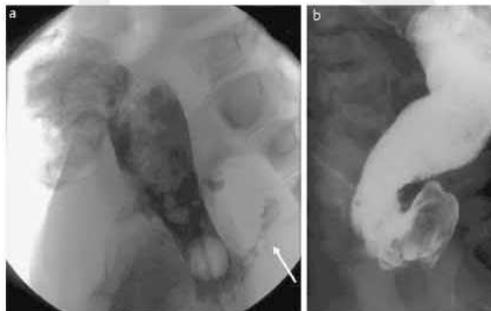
Radiographic finding of a patient with HD (#7) after Duhamel procedure with a pelvic abscess, dorsal fistula (↑) (a) and blind loop syndrome (b).
